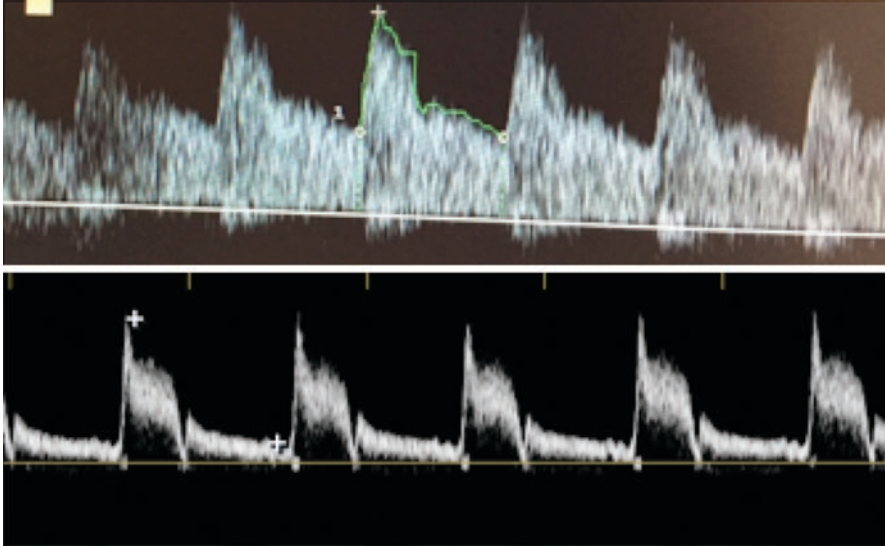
UP: Spectral Doppler waveform of MCA (low resistance spectral pattern). Down: Spectral Doppler waveform of external carotid artery (ACE) (high resistance spectral pattern)
